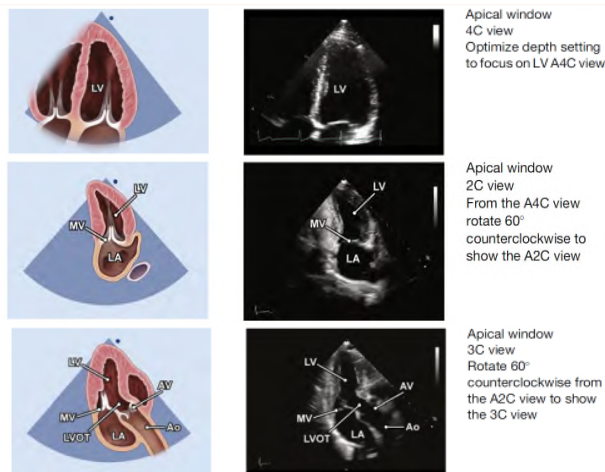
Apical 4C, 2C and 3C views.
